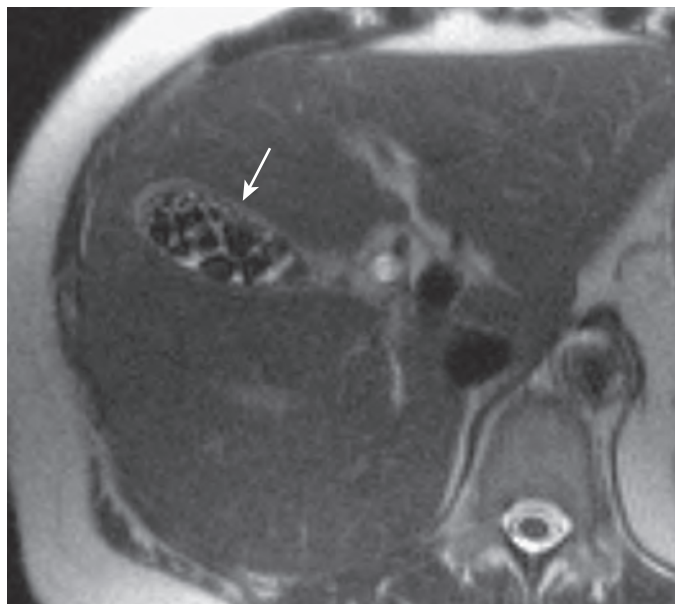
MRI appearance of gallstones. Axial T2-weighted HASTE image demonstrates multiple low signal intensity filling defects in gallbladder lumen (arrow).
